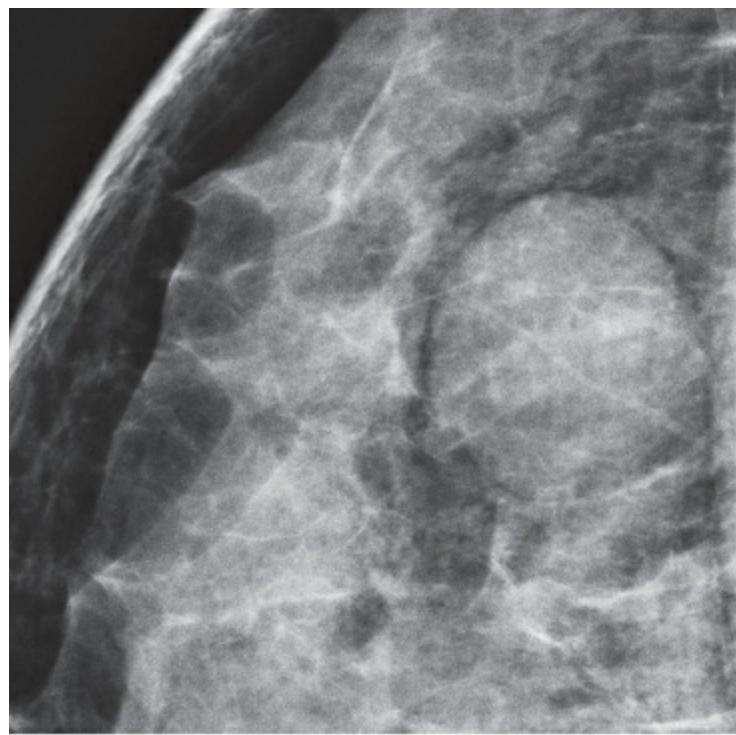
DENSITY: EQUAL DENSITY. Oval, half-circumscribed, half-obscured, EQUAL DENSITY mass. Outcome: simple cyst at ultrasound.
